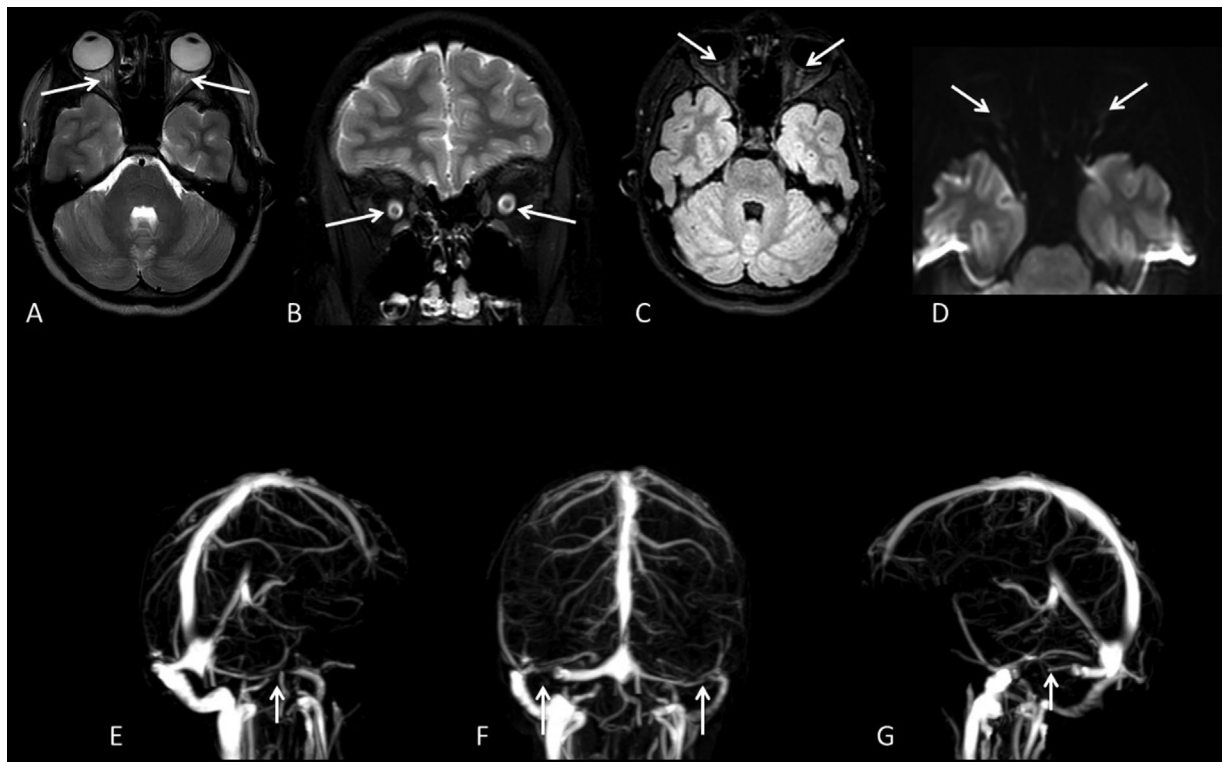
(A,B): T2-weighted axial and coronal sequences showing distension of the optic nerve sheath, which was stable relative to a previous study. (C,D) FLAIR and DWI-weighted axial sequence revealing slight protrusion of the optic papilla, characterized by a slight hypersignal on the FLAIR sequence (white arrows), lower than that of the previous study, but not exhibiting hypersignal on the diffusion sequence (white arrows). (E,F,G) Magnetic resonance angiography showing stenosis at the transition between the left transverse and sigmoid sinuses (white arrows), stable relative to that of the previous study, highlighting material characterizing artefact with magnetic susceptibility contralaterally consistent with the stent (white arrow).
